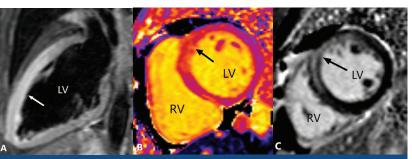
Cardiac magnetic resonance imaging (MRI) findings consistent with typical characteristics of myocarditis; A) MRI (2-chamber view) shows a high intensity area of the left ventricular wall on T2-weighted short-tau inversion recovery STIR, consistent with myocardial oedema in apical 2/3 of the anterior, anteroseptal and anterolateral wall (arrow); B) MRI native T1 mapping (SAX; short axis view) shows significantly increased native myocardial T1 values - mean value 1267 ms in comparison with normal myocardium mean value of 1025 ms in the same area (arrow), where native myocardial T2 values were also increased - mean value 70 ms in comparison with normal myocardium mean value of 53 ms (image not shown); C) MRI (SAX view) shows post-contrast enhancement on LGE of mid-wall distribution in the same area (arrow). LV- left ventricle, RV- right ventricle.
